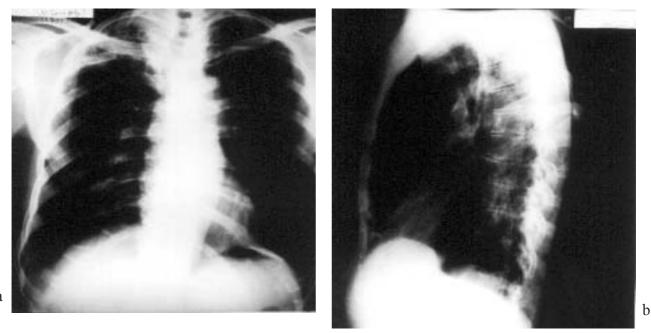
Chest radiography after the treatment
